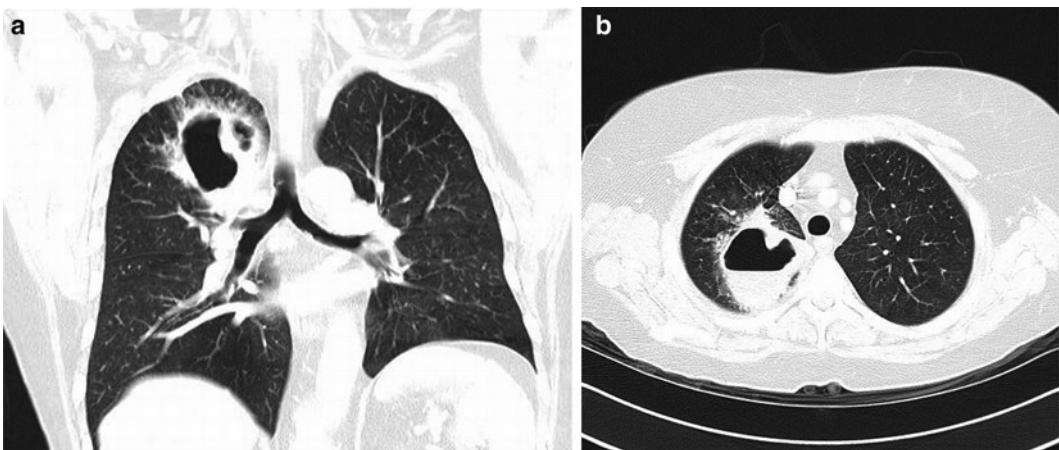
Chest CT scans (a) coronal and (b) transverse of a patient with a right upper lobe lung abscess distal to an obstructing carcinoma. The typical thick walled appearance of the abscess can be appreciated. Since the CT scan is performed in the supine position the air-fluid level is only seen in the transverse plane. This patient had initially presented with a right upper lobe pneumonia 4 weeks previously. Following antibiotic treatment the patient had no symptoms related to the abscess at the time of admission for right upper lobectomy. These patients are at risk for soiling of uncontaminated lung regions during surgery from pus in the abscess. The optimal method of lung isolation is with a DLT.
